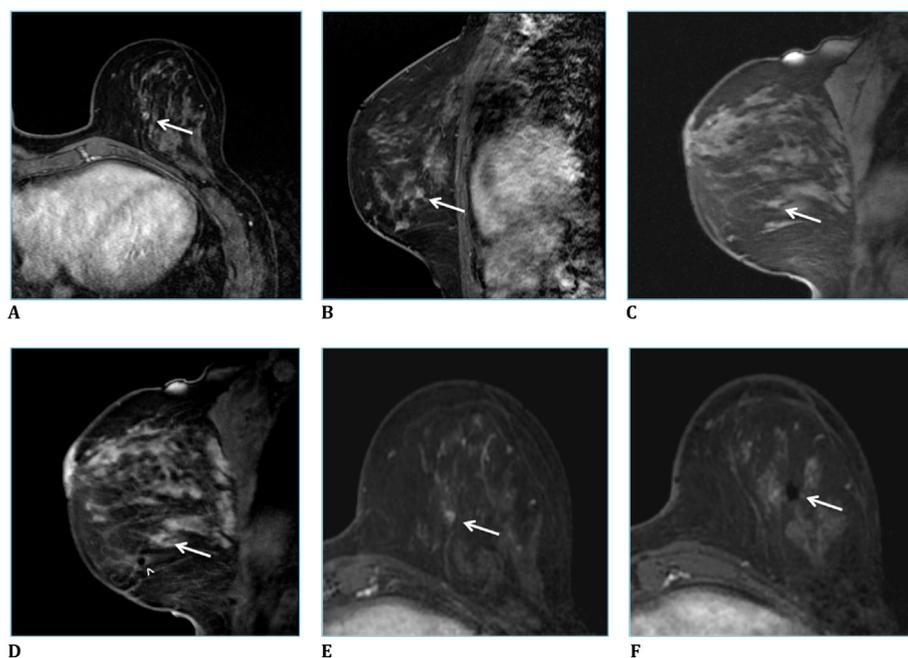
50 year-old female with history of prior contralateral breast cancer undergoing high risk screening MRI. Initial biopsy for an enhancing mass revealed epithelial hyperplasia. Re-biopsy was recommended at 6 month follow up because tissue marker was inferior and lateral to mass. Final pathology demonstrated IDC. Upon retrospective review, initial targeting was inaccurate and this case should have been considered discordant and re-sampled immediately.
